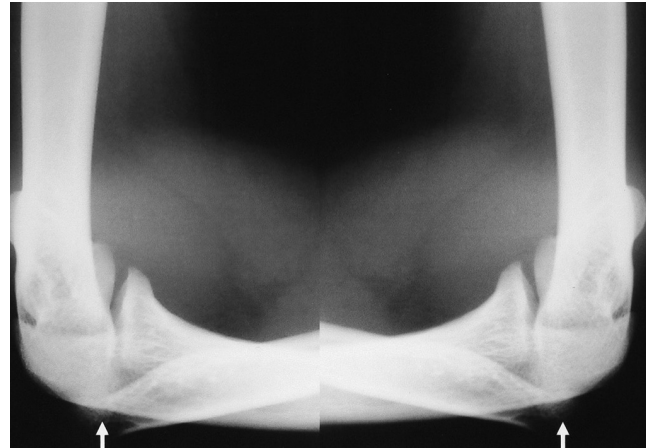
Simple radiography of both elbows show dysplasia and dislocation of radial heads (arrows).
